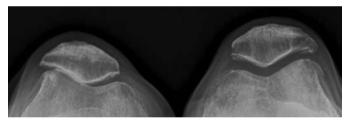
Knee radiograph with PF joint OA
